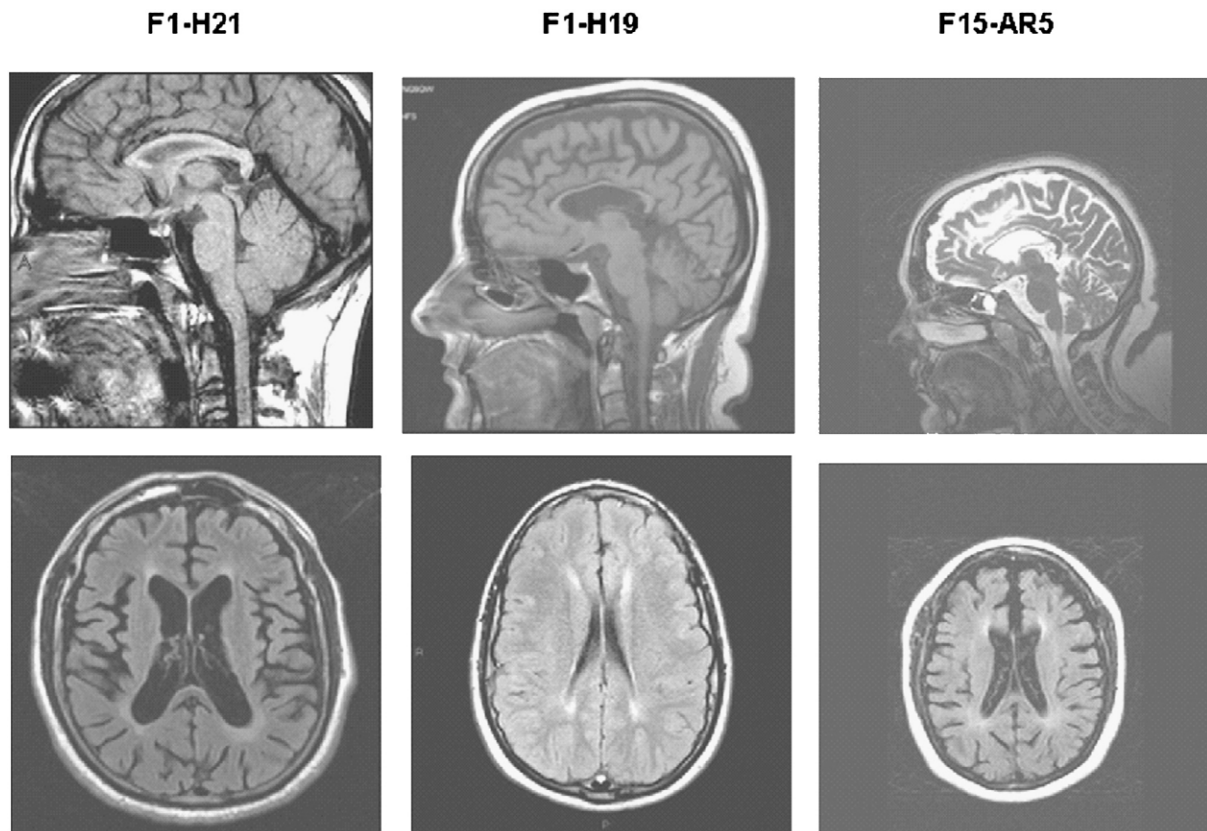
Brain MRI (sagittal and axial sections) in Italian patients harboring mutations in the *ZFYVE26* (*SPG15*) gene. Images in two patients (H19 and H21) identified in family F1-761 [4,7], and in patient F15-AR5 showed thinning of the rostral corpus callosum, leukoencephalopathy, and fronto-temporo cortical atrophy. These features have worsened over the past 5-years, since we first reported ARHSP-TCC cases in the Italian population [4].
